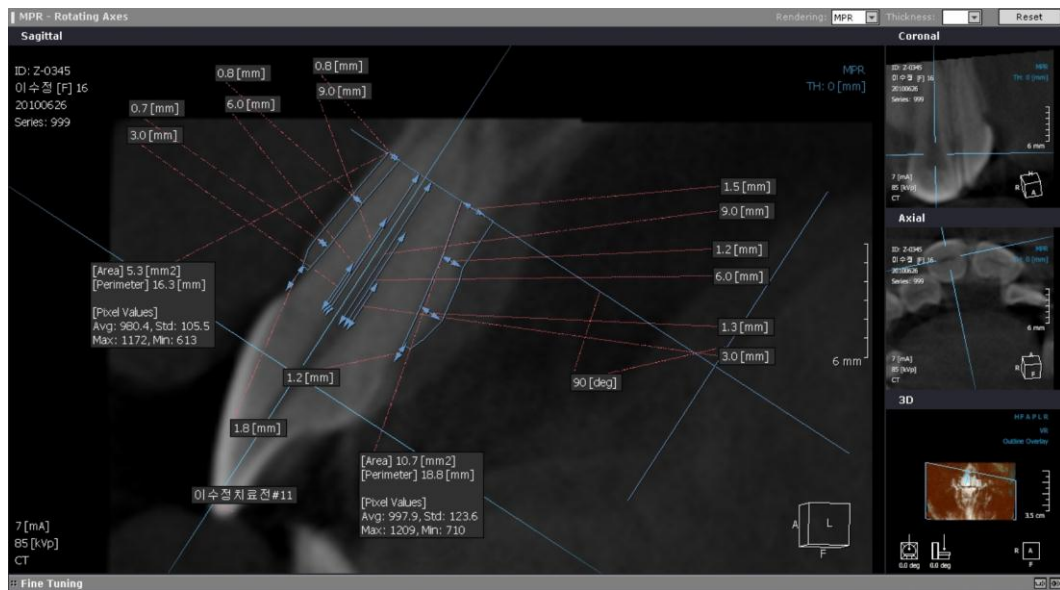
CBCT analysis of #11 before Treatment ( T1 )
